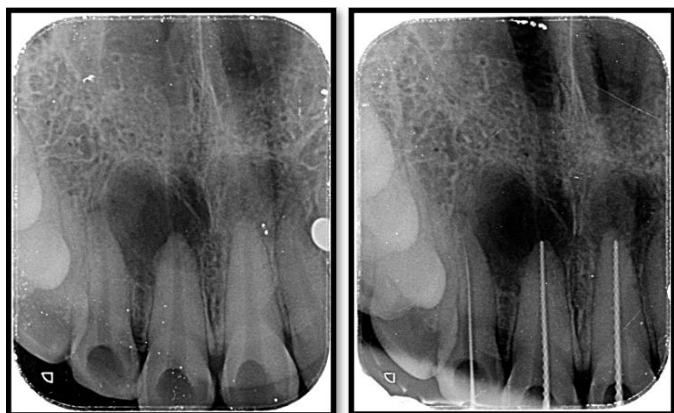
Preoperative radiograph of tooth 11,21,12
